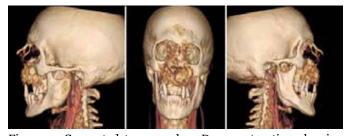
Computed tomography 3D reconstruction showing the mass in the upper maxilla, invading the left alveolar process, the hard palate, the nasal cavity and the base of the orbit.
